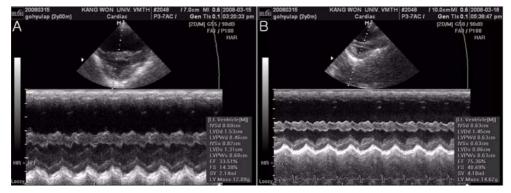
The M-mode echocardiography of this case taken at left ventricular papillary level. A: Before the initiation of medical treatment. The M-mode echocardiography showed marked reduction of fractional shortening (%FS; 14.38%), left ventricular ejection fraction (LVEF), flattening of interventricular septum and marked right ventricular dilation. B: 3 days after the medical treatment including diuretics (furosemide and spironolactone), angiotensin converting enzyme inhibitors (enalapril), inotropics (pimobendan), and nitrate patch. The M-mode echocardiography showed marked improvement in %FS (40.69%) and LVEF, although right ventricular dimension was not much changed.
